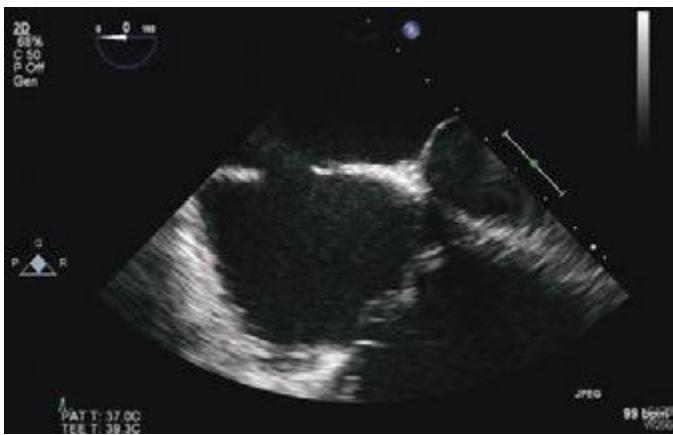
16 Transesophageal echocardiogram of a secundum ASD. The ASD is seen as “dropout” in the interatrial septum between the left atrium (LA) and RA (left). Doppler color flow imaging shows blue in the RA consistent with left-to-right flow (right).
